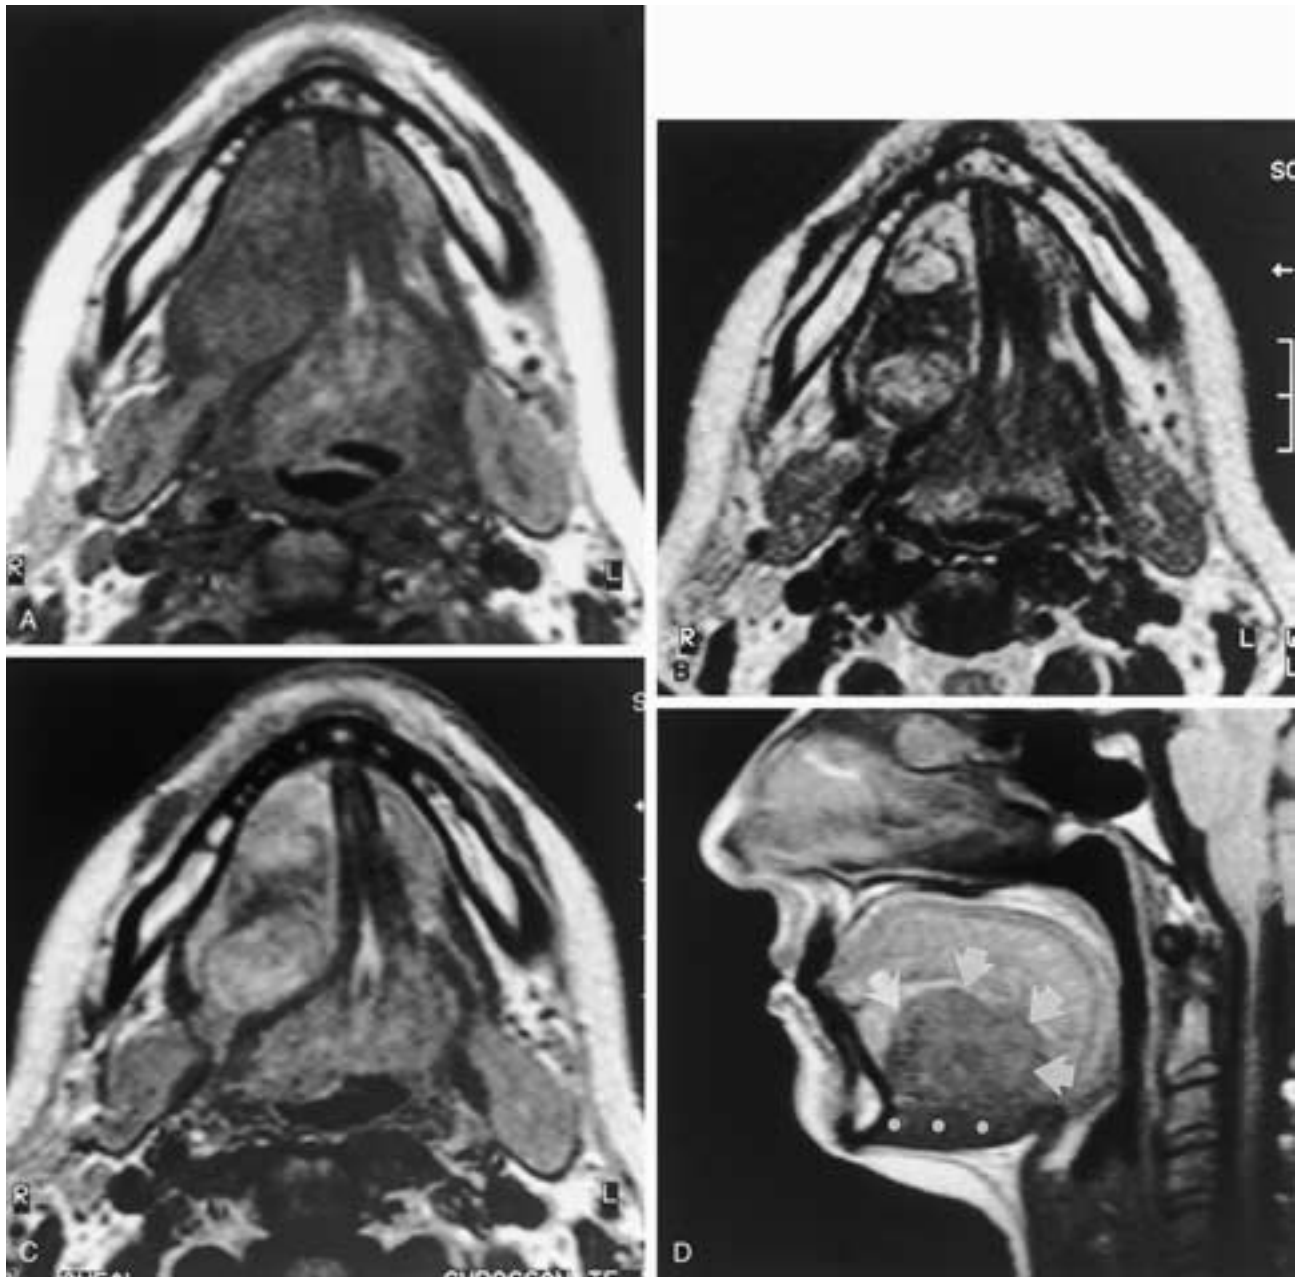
Adenoid cystic carcinoma of the right sublingual gland (cribriform and solid components). A, Axial T1-weighted MR image demonstrates a right sublingual space mass with signal intensity almost isointense to muscle, making definition difficult. B, The T2-weighted image reveals areas of moderate and low signal intensity corresponding to the areas of cribriform and solid components, respectively. C, Axial T1-weighted MR image after contrast administration reveals enhancement of the cribriform areas, but the solid central component demonstrates significantly less enhancement. D, Sagittal T1-weighted image optimally demonstrates the tumor location cephalad to the mylohyoid muscle fibers (*dots*) and the tumor size (*arrows*).
